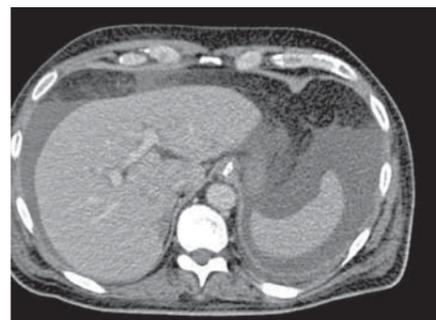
CT-scan 5 days post-PPPD showing intra-abdominal biloma as a result of HJ leakage.
